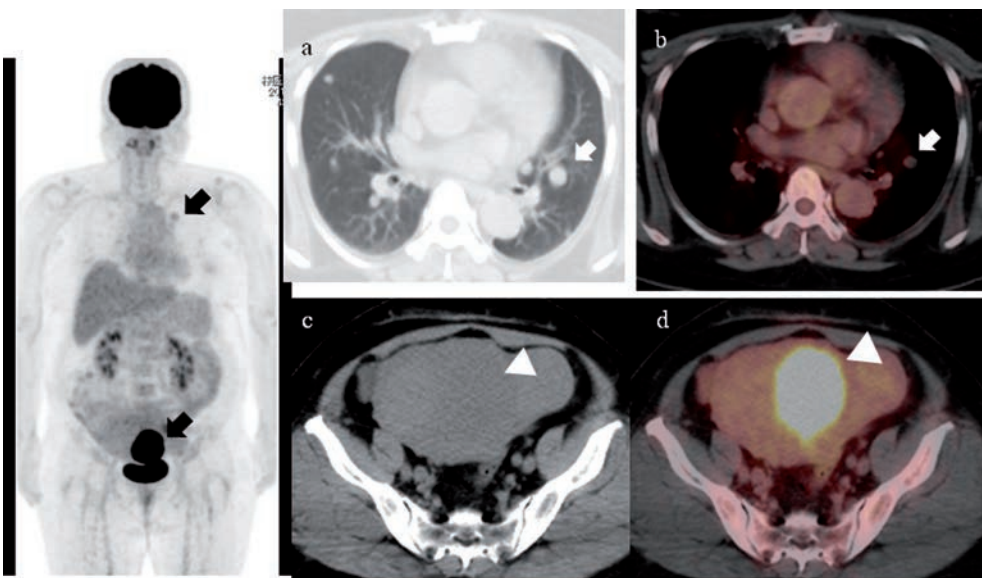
FDG uptake on PET-CT. SUVmax on the lung lesions is 2.5 (a, b), whereas on the uterus it is 24.7 (c, d).
